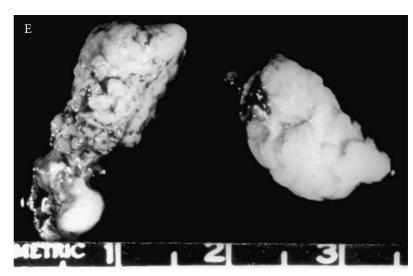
Relief of carinal obstruction due to tumor. A, Computed tomography scan demonstrating complete obstruction of the left main bronchus and partial obstruction of the right by squamous cell carcinoma. B, Bronchoscopic view showing the severity of blockage. C, Right main bronchus opened by bronchoscopic core-out. D, After both main bronchi have been opened. Tumor remains at the bifurcation to avoid the danger of perforation into the mediastinum. Carinal resection and reconstruction followed.
